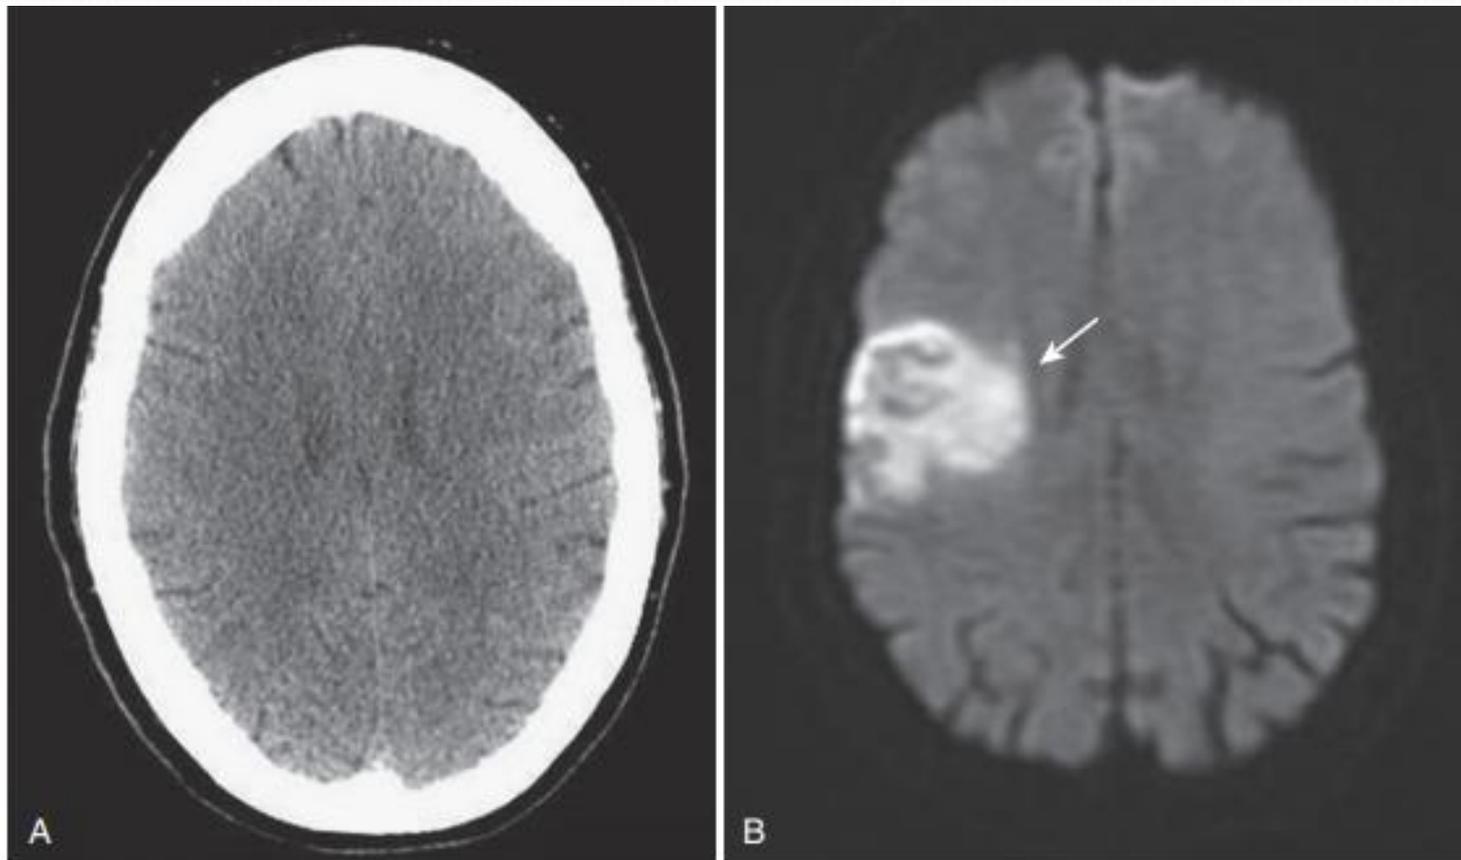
Computed tomography (CT) and diffusion-weighted magnetic resonance imaging (MRI) in acute stroke. A, The CT scan in this patient with symptoms for 2 hours prior to the study is normal. B, A diffusion-weighted MRI scan on the same patient a few minutes later shows an area of abnormally bright signal intensity in the right frontoparietal region (white arrow). Diffusion-weighted imaging (DWI) is an MRI sequence that can be rapidly acquired and which is extremely sensitive to detecting abnormalities in normal water movement in the brain so that it can identify a stroke within 20 to 30 minutes after the event.
